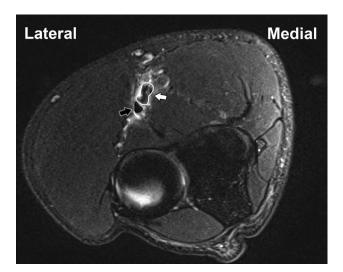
Representative axial T2 fat-saturated magnetic resonance imaging of short head (SH) tendinopathy (white arrow) relative to a normal long head tendon (black arrow); the SH demonstrates abnormal caliber change and abnormal signal intensity.
